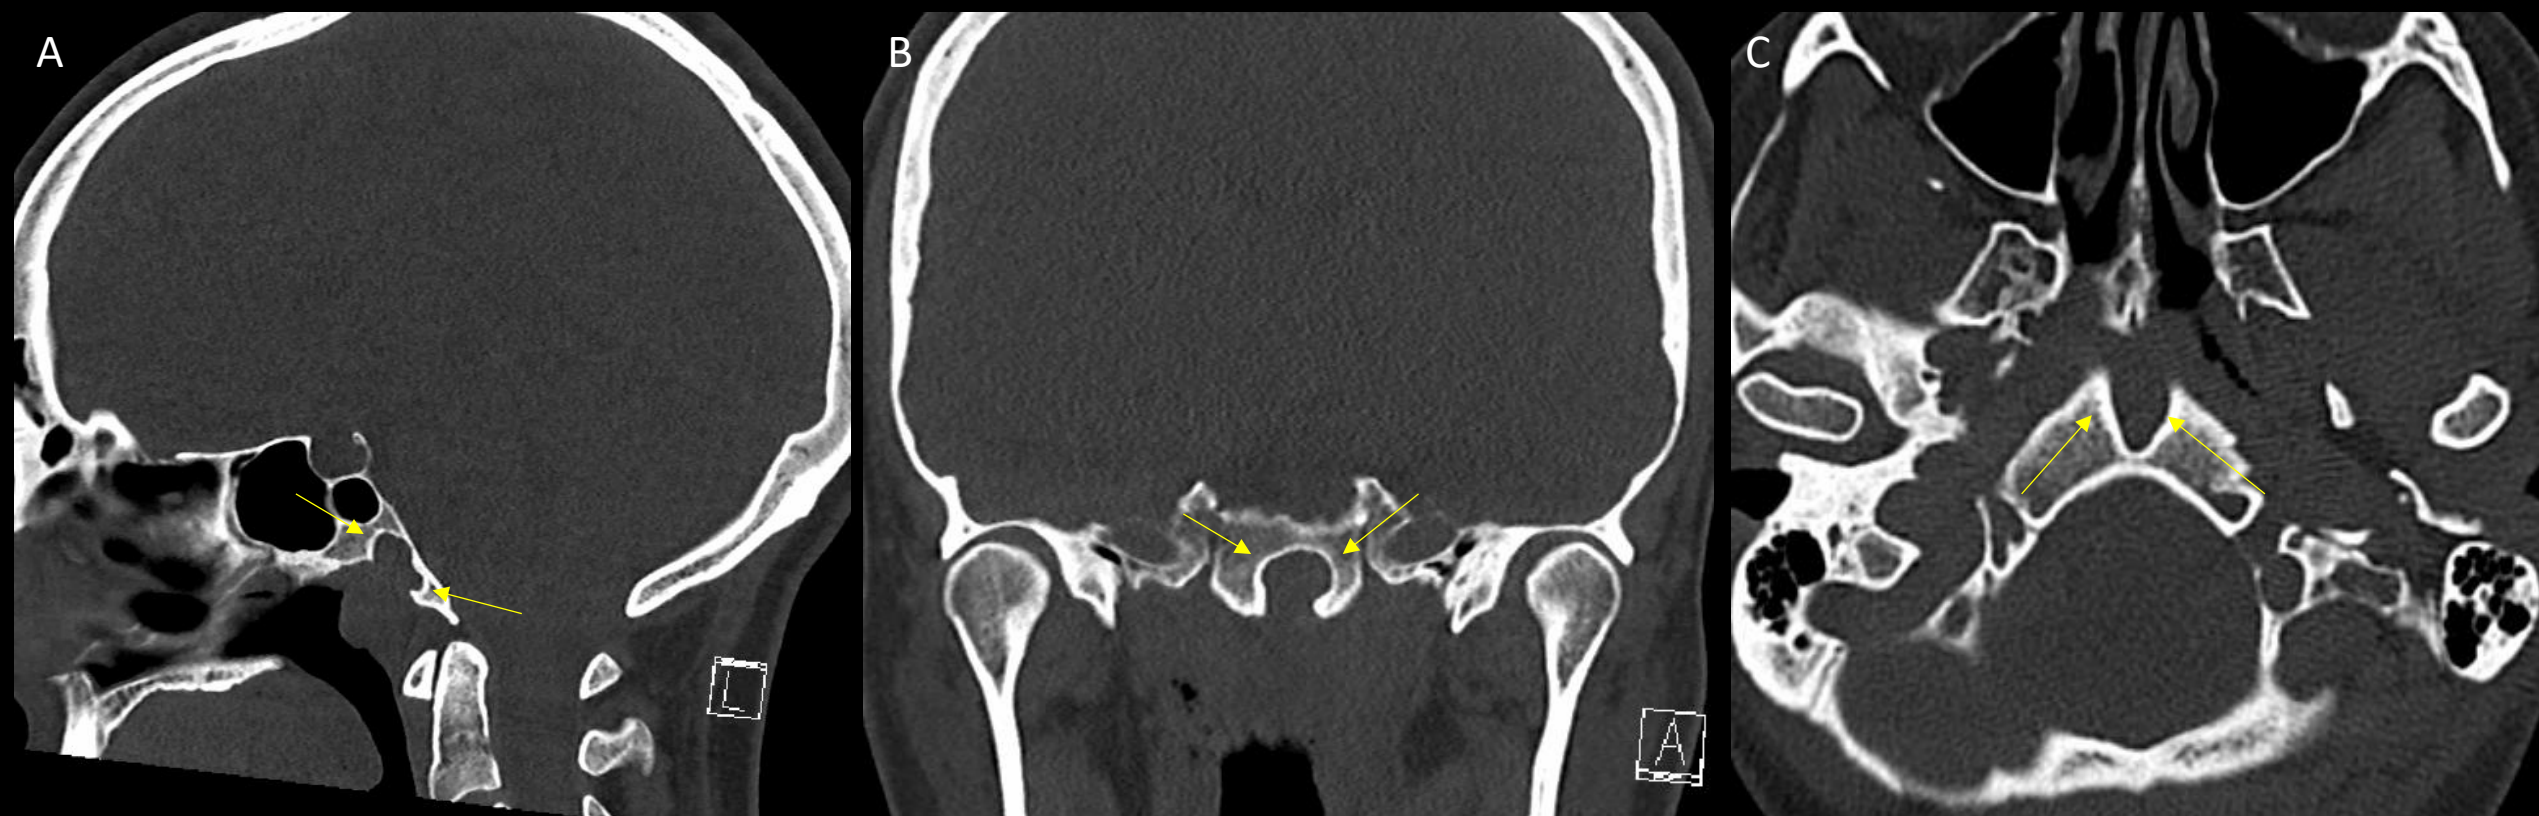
CT in sagittal (A), coronal (B) and axial (C) CT planes showing well-demarcated defect in the clivus involving anterior margin with sclerotic borders (yellow arrows).
